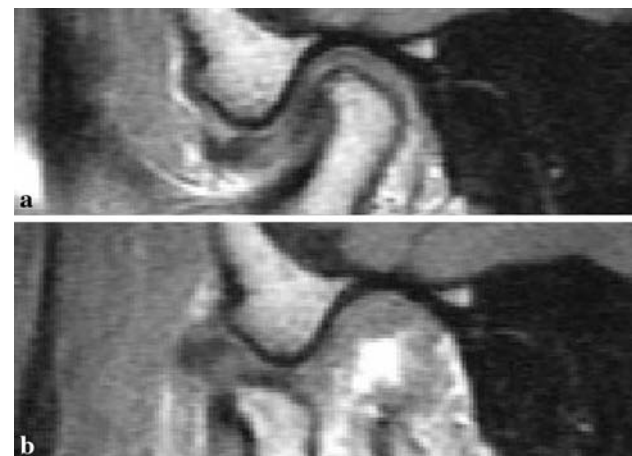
MRI of ADDwoR: a closed and b open mouths
